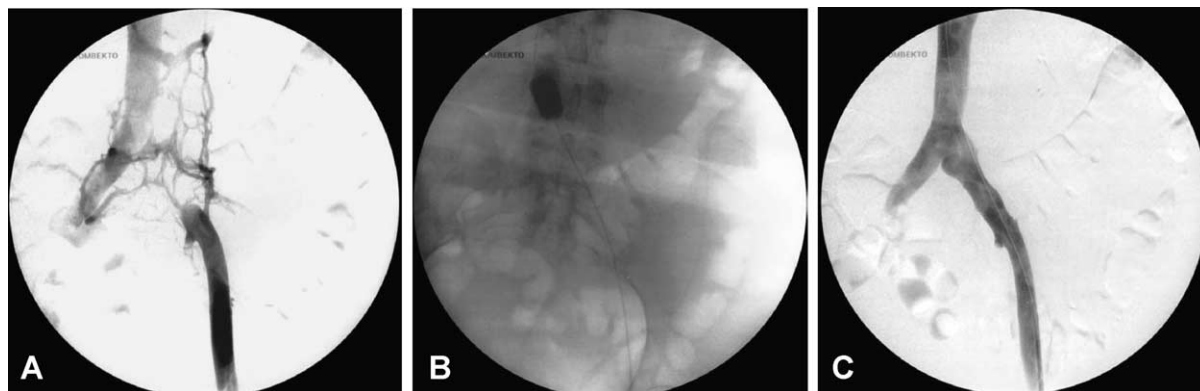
A 43-year-old woman with MEN syndrome suffered an ilio-femoral thrombosis 3 days after pancreatic resection. After clearing fresh thrombotic material venography showed residual thrombotic occlusion of the common iliac vein with collateral venous drainage (TYPE II thrombectomy) (A). Using a Terumo[®] guide wire the thrombus was passed under radiographic control (B) and completely extracted by a wire-guided balloon catheter (C). Oral anticoagulation was continued for 6 months. Duplex ultrasonography showed that the iliac veins were patent 23 months later.
